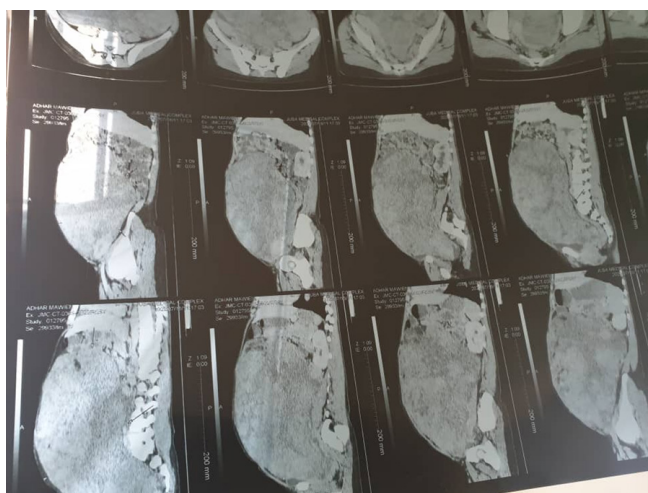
CT scan with contrast of an abdominopelvic mass
